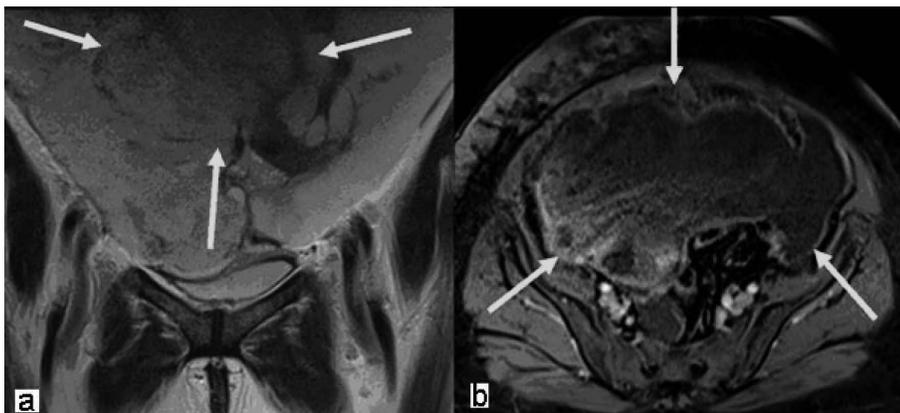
Abdomino-pelvic MRI, A: T2 weighted, B: T1-weighted dynamic contrast enhanced MRI series. A heterogeneous tumoral mass completely occupying the pelvic cavity in the initial evaluation.
